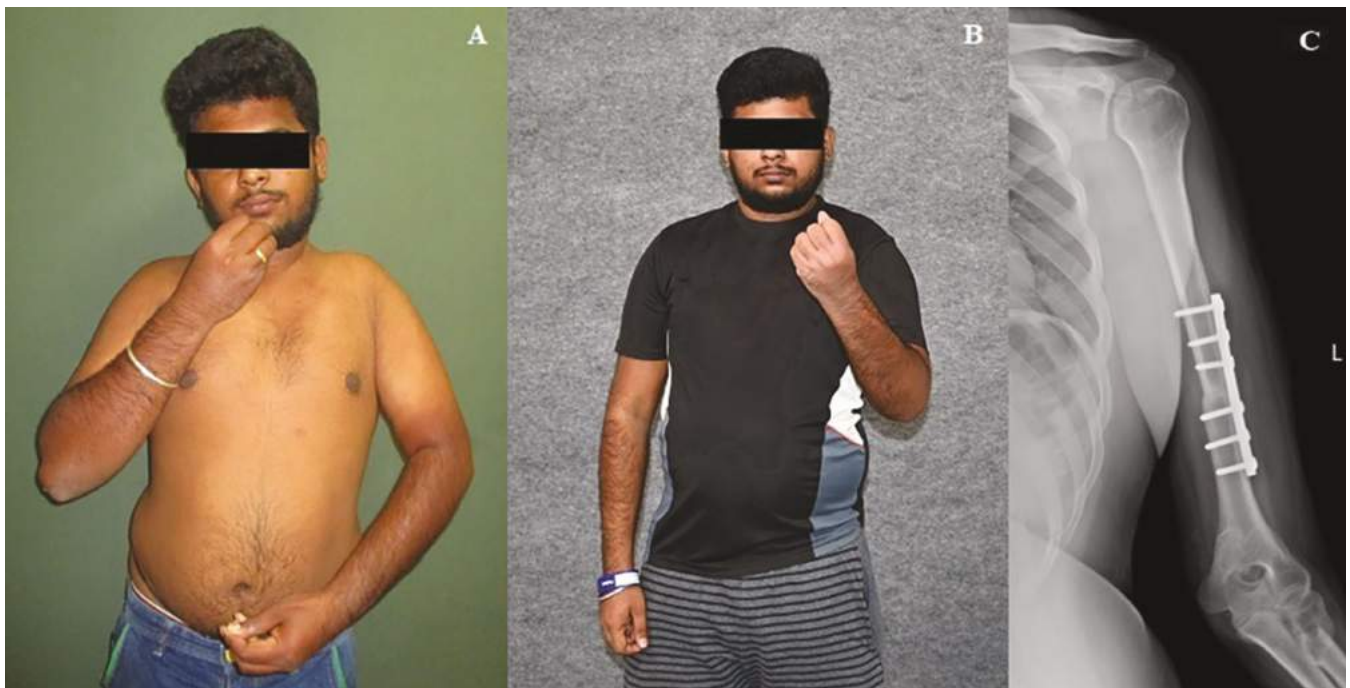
A 24-year-old male with left sided upper extended brachial plexus palsy. The arm hangs down in an inwardly rotated position. A. Same patient, after external rotation osteotomy of humerus, with improved position of the arm and better hand to mouth and face reach. B. Radiograph showing good union at the osteotomy site. C.
